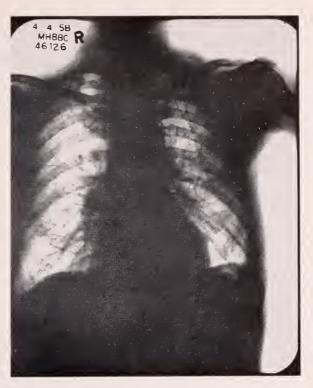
X-ray showing multiple punched out bone lesions.
